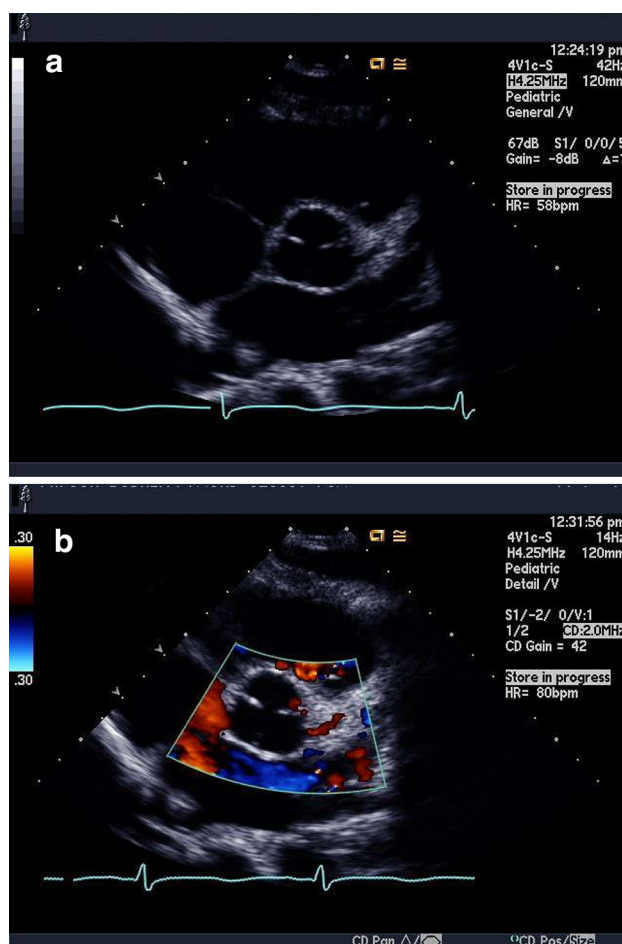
False negative: normal appearing left main coronary artery in a 2D and b color Doppler (red)
